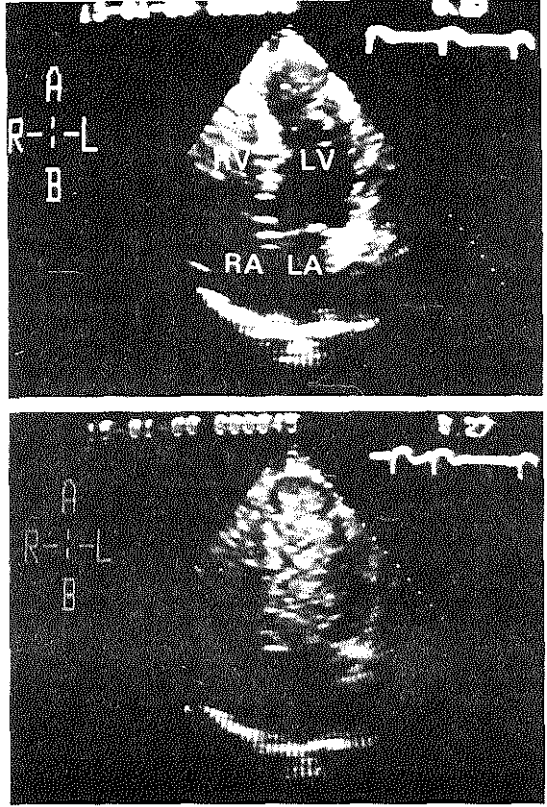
Apical four-chamber views before (upper panel) and after (lower panel) left ventricular opacification by echo contrast via a pulmonary wedge injection in a patient with an apical aneurysm. Wash-out of echo contrast from within the aneurysm was delayed.
